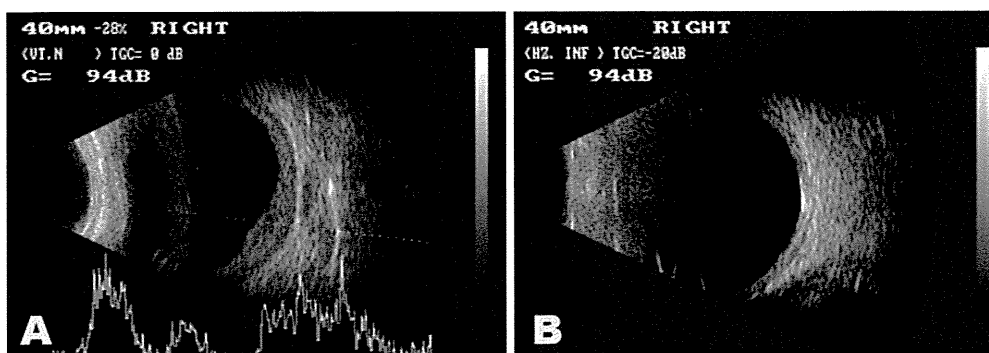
Ultrasonography of the eye. A The thickening of episcleral and scleral tissue indicates posterior scleritis. B One month after treatment with oral mycophenolate mofetil and subcutaneous methotrexate, the scleral edema resolved.
